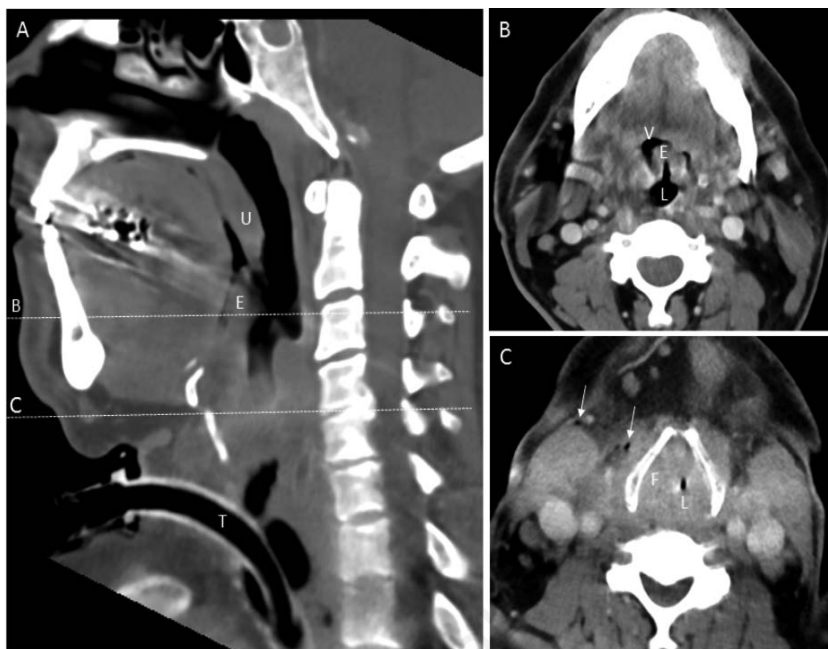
CT images of the critical upper airway obstruction. Midsagittal (A) and axial CT images at the level of epiglottis (B) and just above the vocal cords (C) showing laryngopharyngeal soft tissue thickening of the uvula (U), epiglottis (E) and larynx causing narrowing of the lumen (L) and upper airway obstruction. Small amounts of soft tissue air (arrows) related to prior acute surgical tracheotomy and the tracheal cannula/tube (T).
